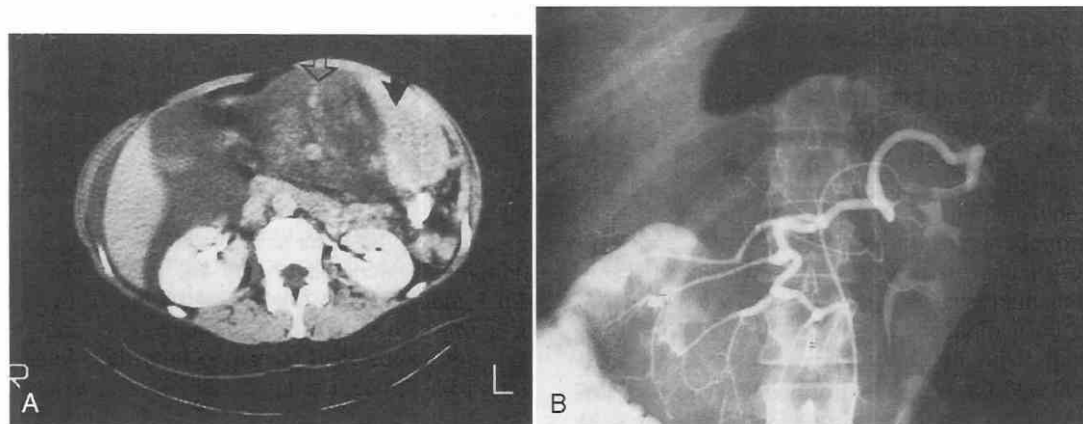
A, Large mass in the midabdomen (*open arrow*) that is adjacent to the spleen (*arrow*). The mass was the tail of the pancreas, which was edematous because of torsion of the gland. B, Angiogram shows a circular configuration of the splenic artery and a cutoff at the end. (From Sheflin JR, Lee CM, Kretschmar KA: Torsion of wandering spleen and distal pancreas. *AJR* 142:100; copyright by American Roentgen Ray Society, 1984.)
